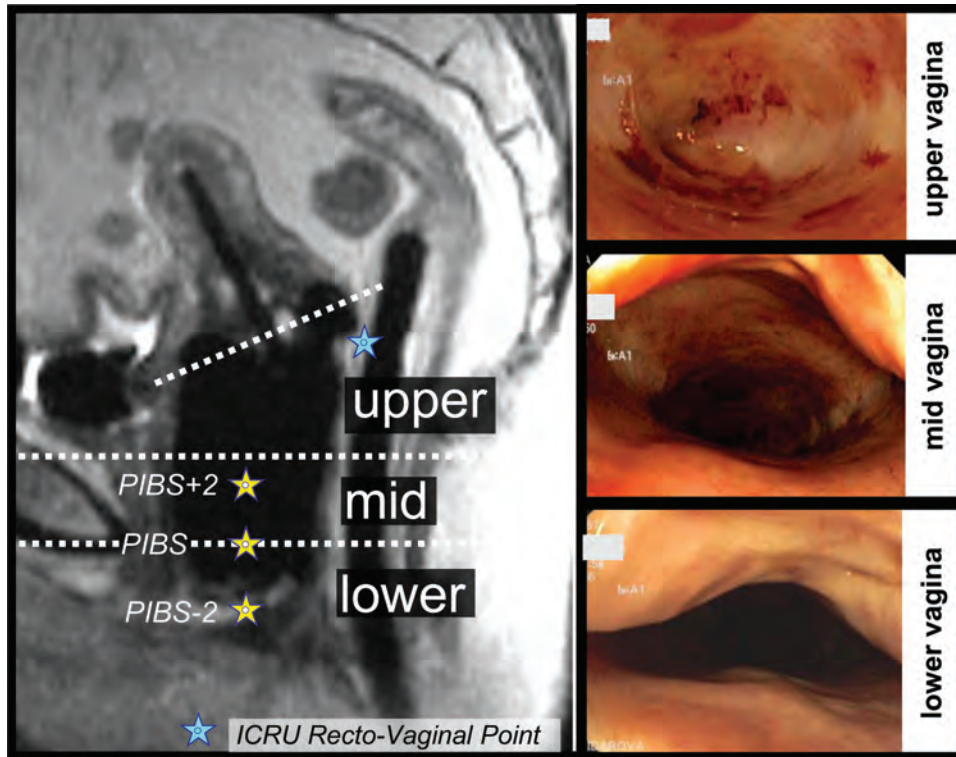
MRI sagittal view of the vagina with applicator, rectal probe, and bladder balloon in place. Lines indicate the cranial borders of the upper, mid, and lower portion of the vagina. The lower vaginal line, as the transition between lower and mid-vagina, is defined at the level of the posterior-inferior border of the symphysis (PIBS, as denoted by asterisk, together with the other vaginal points in Figure 6.4). Endoscopic views of typical vaginal morbidity in the upper, mid, and lower portion: dome shape indicative of fibrosis, multiple telangiectasia, and mucosal pallor in the upper vagina; telangiectasia, mucosal pallor, and reduced rugae in the mid vagina; some pallor in lower vagina.
